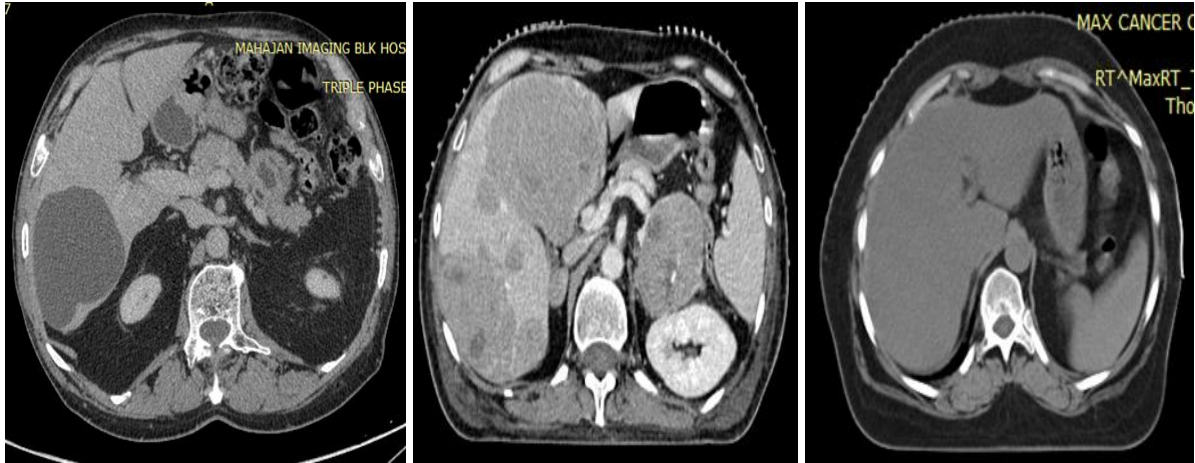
(a), (b) and (c) are the Marked ROI for the HCC, MET and the normal CT scan images of the liver, respectively. The region marked is the tumor portion that is present inside the liver. For the normal liver, the marked area is the complete liver portion of the body.
